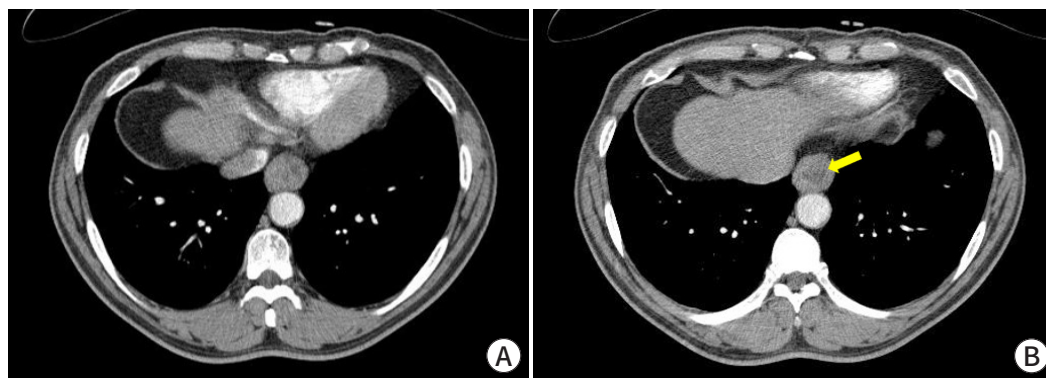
Contrast-enhanced chest CT. (A, B) Asymmetric wall thickening with heterogeneous enhancement and a non-enhanced area (arrow) is evident in the lower esophagus.
